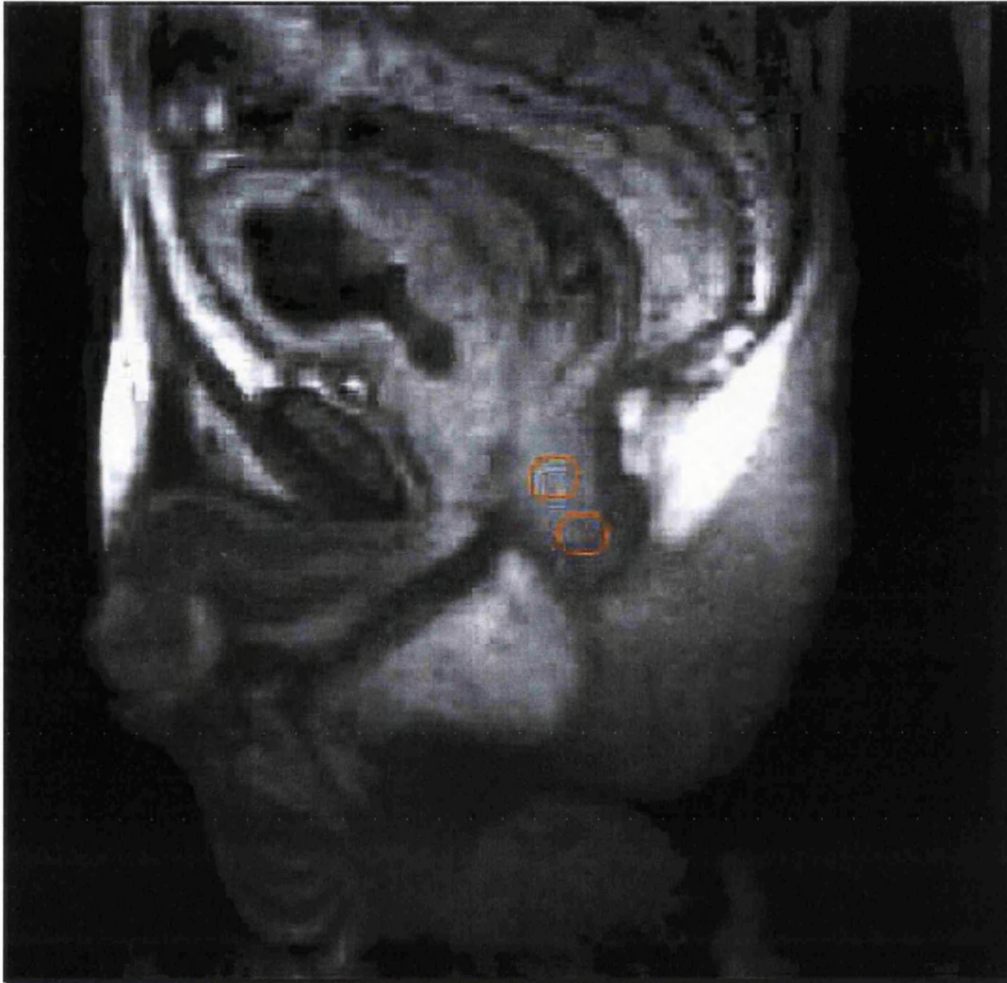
Saggital MRI showing upper and lower anal ROI (orange ellipses)
